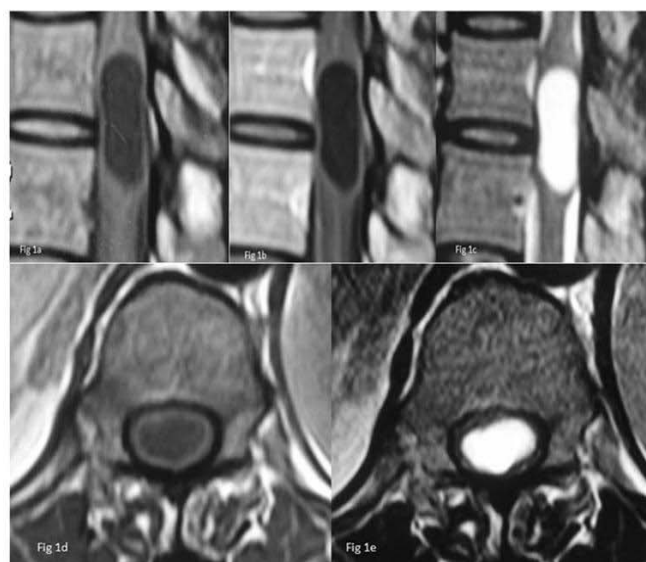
MRI of the dorsal spine.
